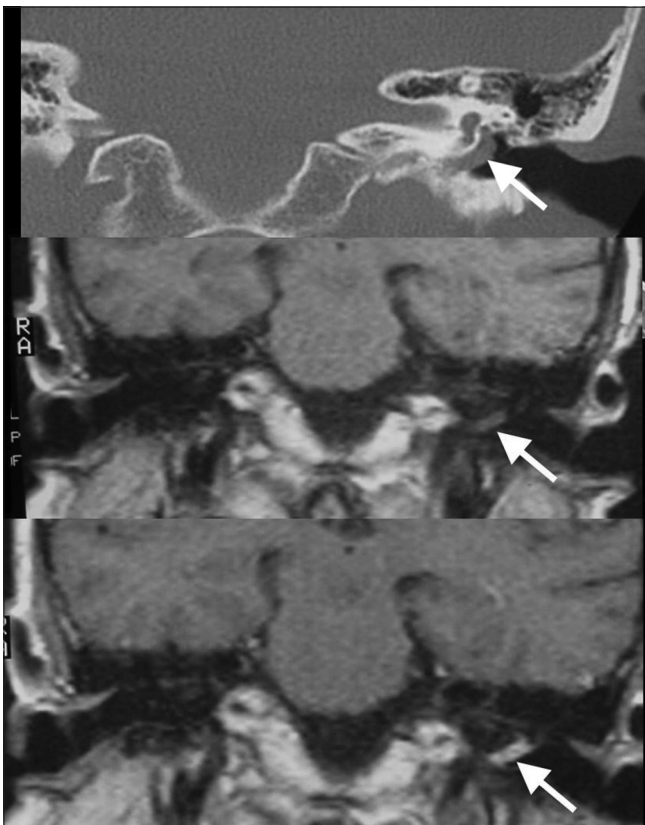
Coronal CT, MRI plain and contrast images of the left temporal bone show soft tissue mass over cochlear promontory with enhancement following contrast – glomus tympanicum
